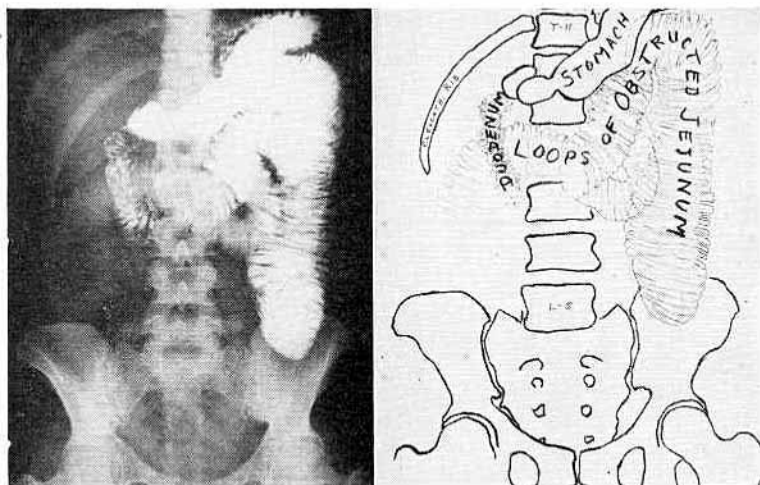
Case II. Ventral projection of abdomen, patient prone, twenty minutes after ingestion of opaque meal. Note the characteristic mucosal markings of jejunum. The small intestine is much shorter during life, and particularly in the absence of anesthesia, than was believed to be the case before the advent of roentgen methods of study (compare Case I). The surprising outcome in this present case is demonstrated in Fig. 419.
